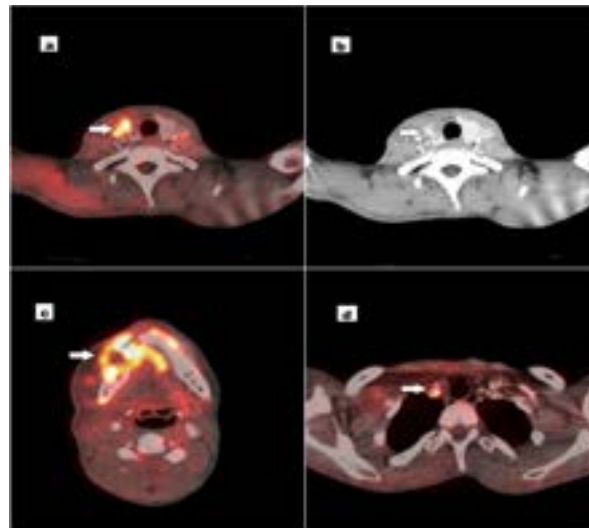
(a and b) FDG- PET CT scan showing metabolically active lesions in (a) right lobe of thyroid (arrow), (c) right border tongue (arrow) - previous wide excision site, (d) right paratracheal node (arrow).
